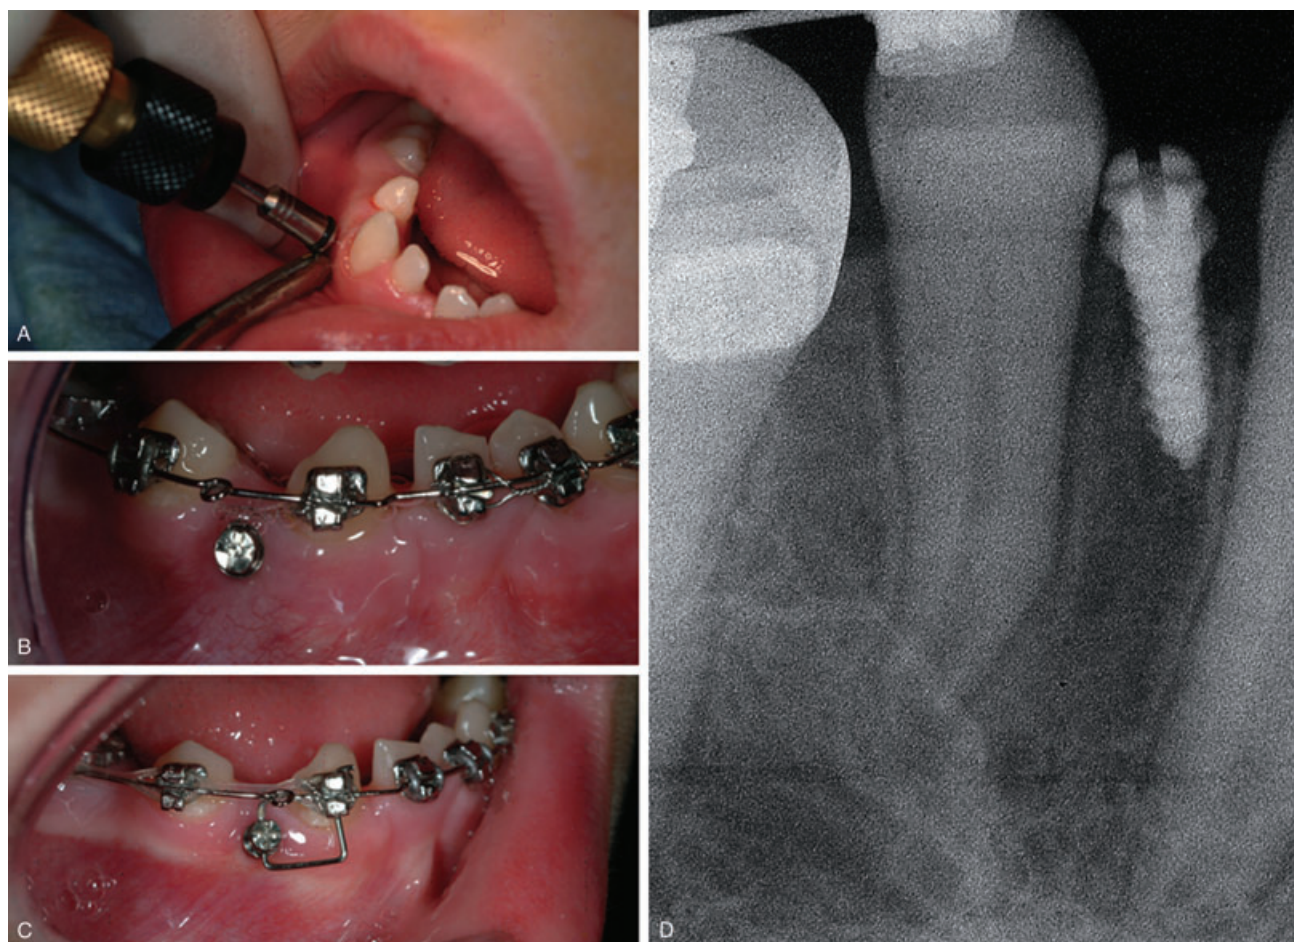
Clinical case showing (A and B) screw placement under local anesthesia, (C) screw with orthodontic appliance in place, and (D) radiograph indicating screw position in the diastema.
